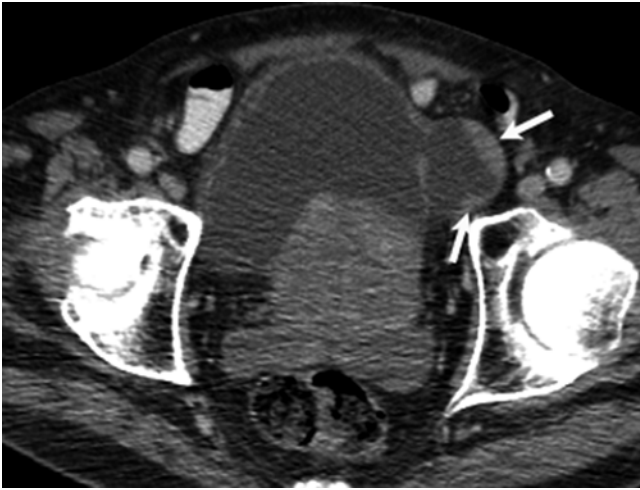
Urinary bladder diverticulum with tumor. Axial contrast-enhanced CT image shows a left-sided urinary bladder diverticulum with nodular wall thickening suspicious for cancer (*arrows*)
